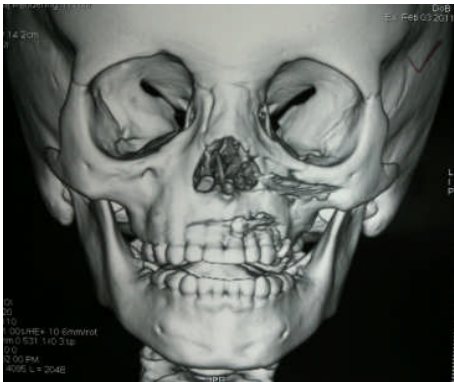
Post surgery 3D CT scan
